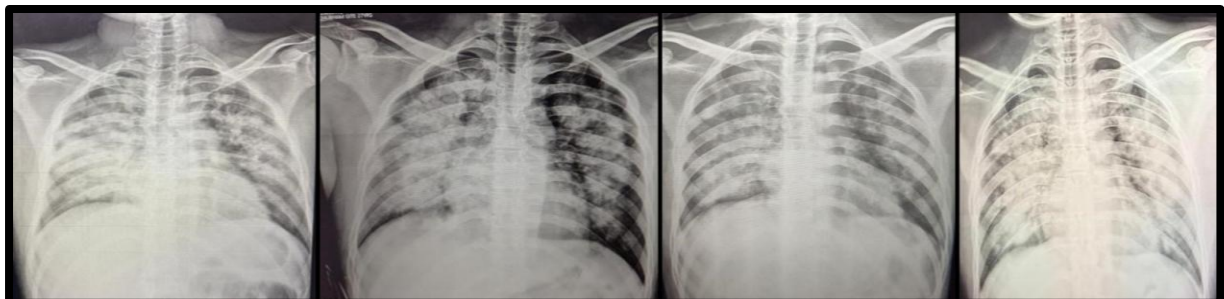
shows series of Chest x-ray changes over a period of time
